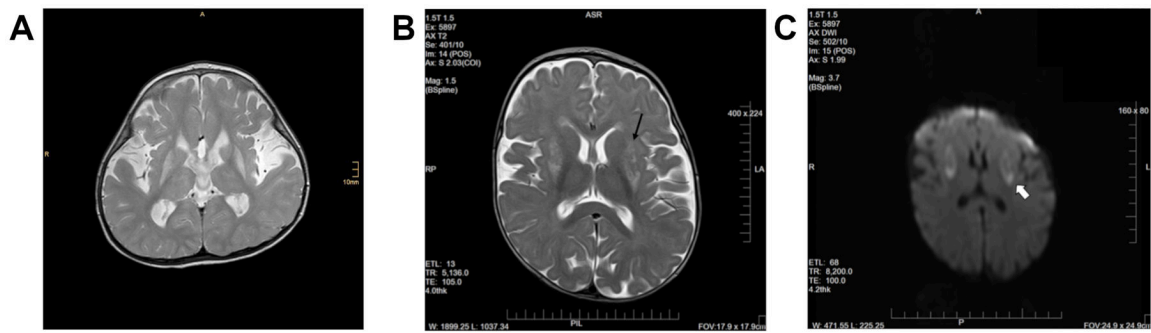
Leigh-like lesions of the basal ganglia in SLC39A8-CDG. Cranial MRI performed in both patients revealed symmetric bilateral T2 hyperintense lesion. In patient 1, pronounced symmetric bilateral hyperintensities, especially of the putamen were noted along with volume reduction of the entire basal ganglia (A). Similarly, patient 2 showed T2 hyperintense lesions of the putamen and caudate nucleus along with abnormal perfusion restrictions (B, C).
